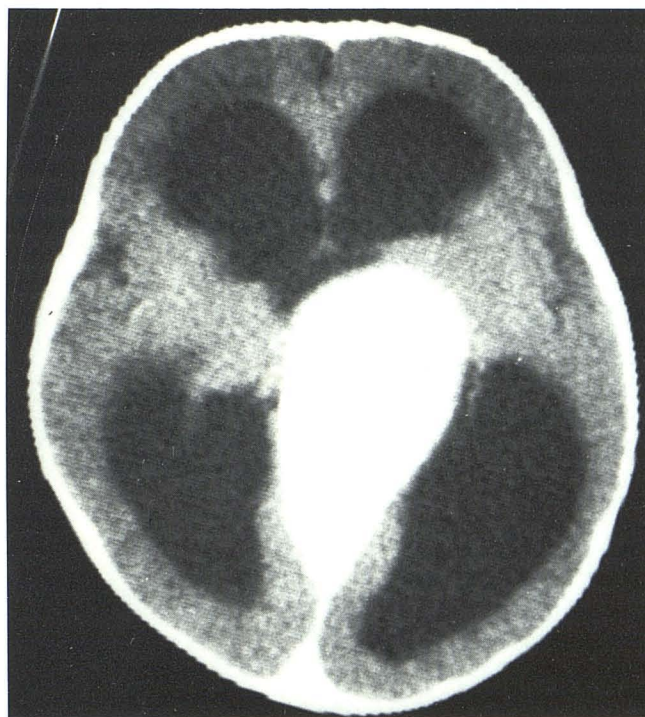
Obstructive hydrocephalus caused by large midline lesion, which was discretely hyperdense on nonenhanced CT and showed intensive enhancement after IV contrast injection.
